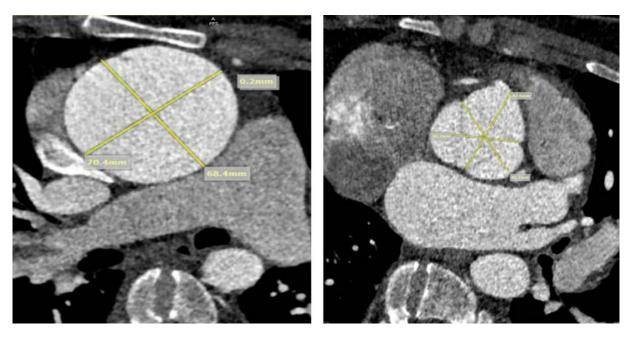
Thoracic computed tomography of the ascending aorta (left), with enlargement of the aortic root shown (right).
